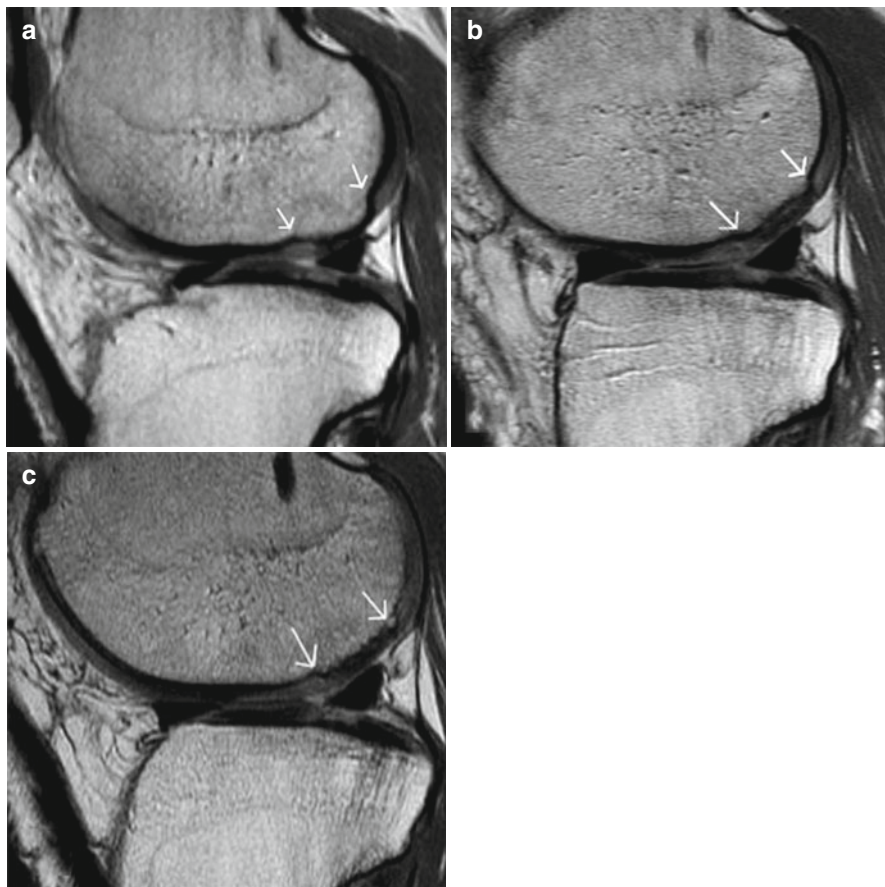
Magnetic resonance images (sagittal plane) of a representative patient with focal chondral lesion of the knee treated with DeNovo NT technique: preoperative (a), at 12-months (b) and at 24 months (c). Arrows mark the margins of the lesion. (Picture reproduced from Farr et al. [25])
